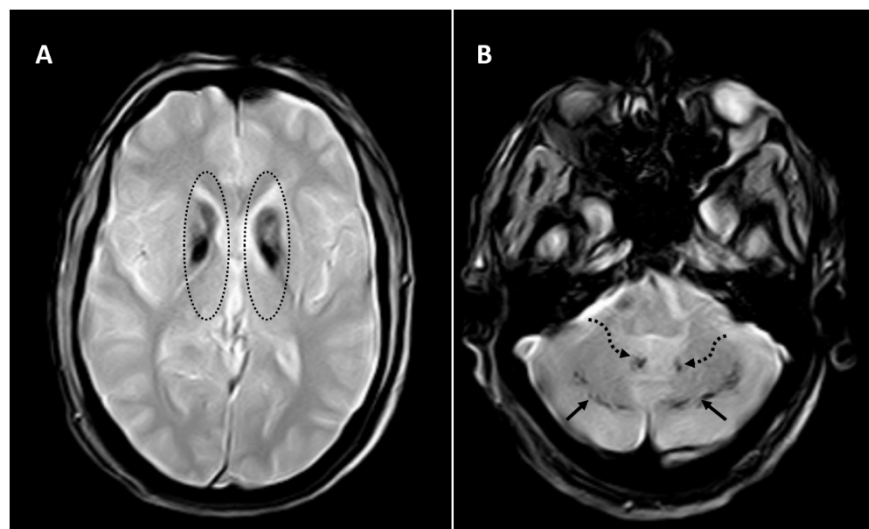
Axial sections of SWI sequence of MRI brain showing susceptibility changes in bilateral caudate nucleus and globus pallidi (dotted circles, A), dentate nuclei (curved dotted arrows, B) and cerebellum (black, arrows, B)
